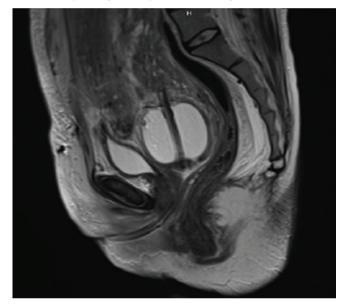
MRI view of the Foley catheter balloon in the lower uterine segment on the first postoperative day *MRI: Magnetic resonance imaging*
